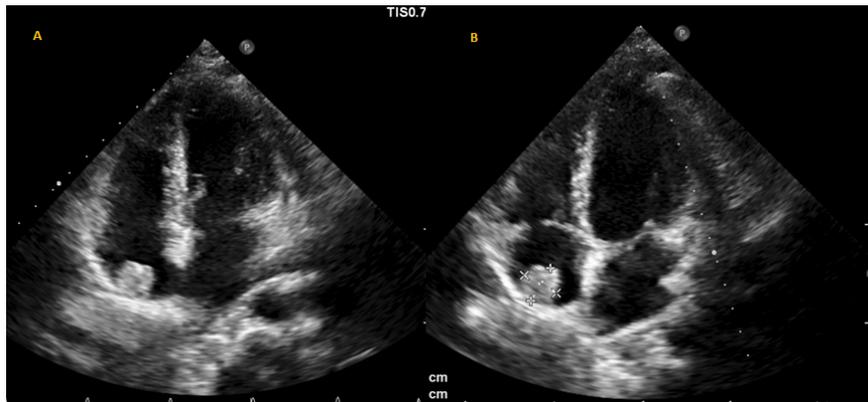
Follow up transthoracic echocardiography
